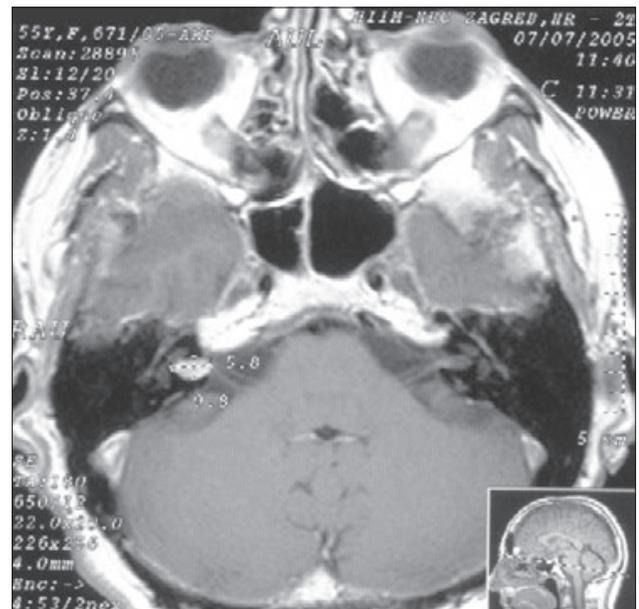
MRI of the brain – expansive formation in the right side inner auditory canal, transversal cross-section.
